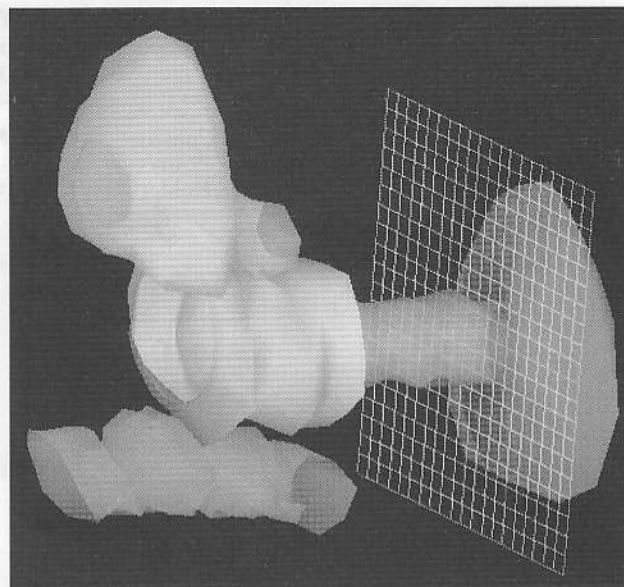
Three-dimensional reconstruction. A preplan CT scan is used to reconstruct the target, bladder, rectum, and vaginal cylinder. A 3D grid object is used to determine optimum needle spacing on the basis of the dose calculation. From this, the template (see Fig 9) is designed and fabricated before treatment.
